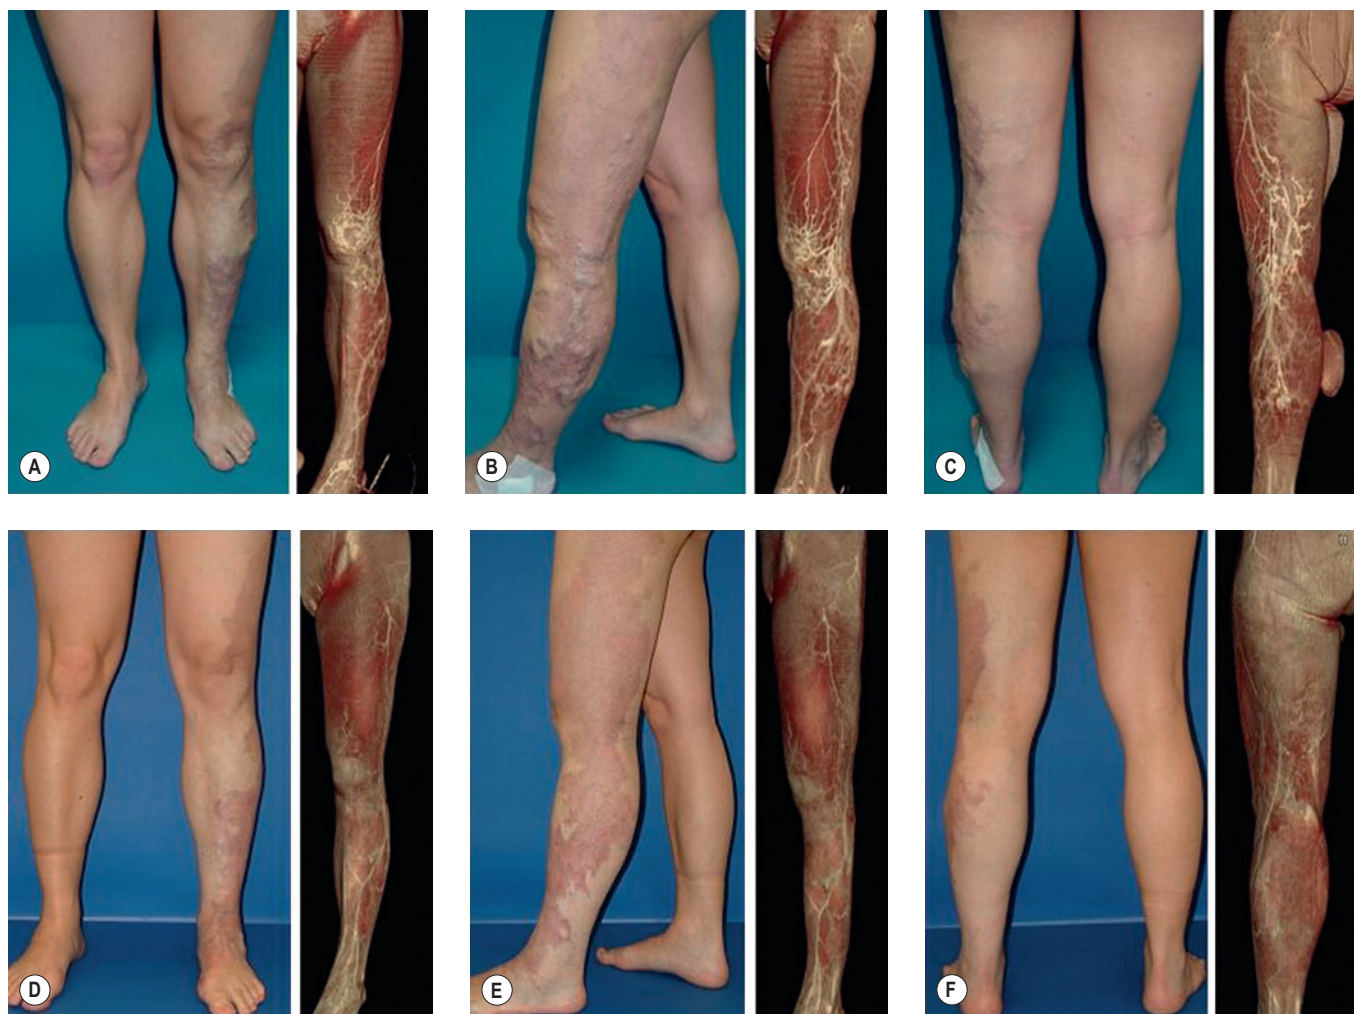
Case Study 16. Clinical and multidetector-row computed tomography venography images from a 25-year-old woman with Klippel-Trenaunay Syndrome. Upper row, initial images; lower row, follow-up images. A and D, Anterior views (left); B and E, lateral views; and C and F, posterior views. (Extracted and used with permission from Arch Dermatol 2009;145:1147.).
